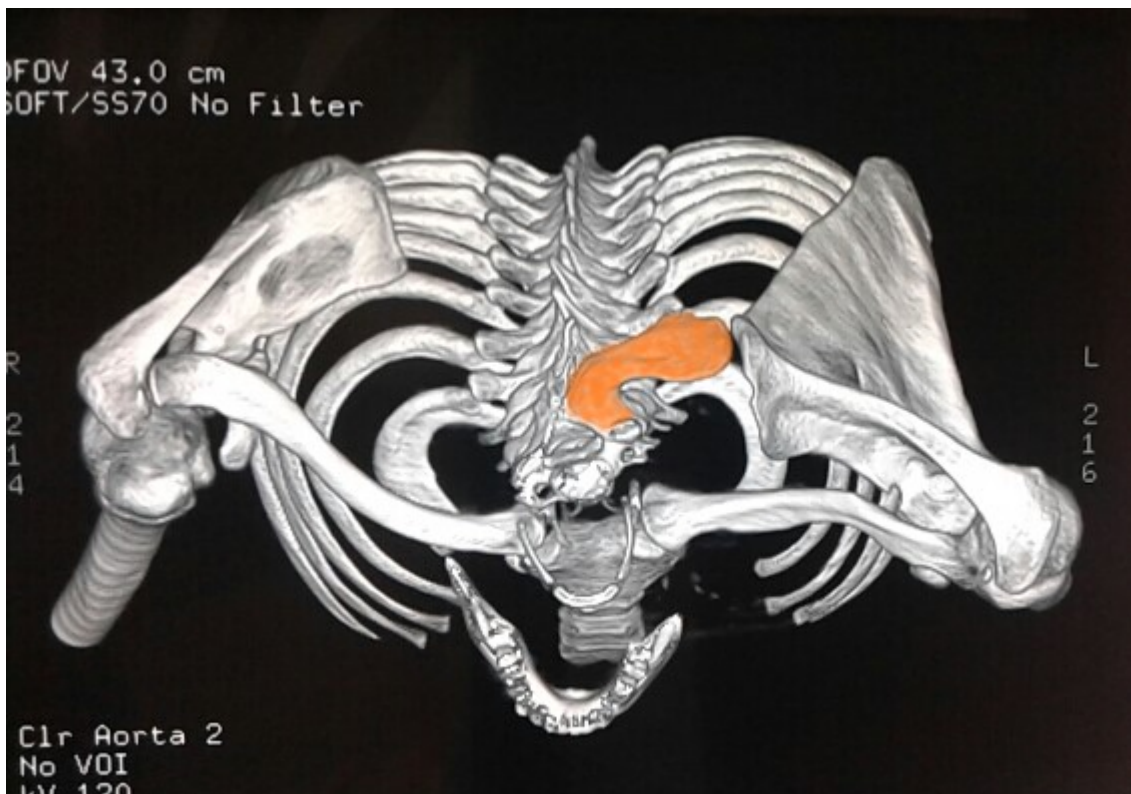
Trunk 3D CT scan; Upper view: Omovertebral bone is colored in orange.
